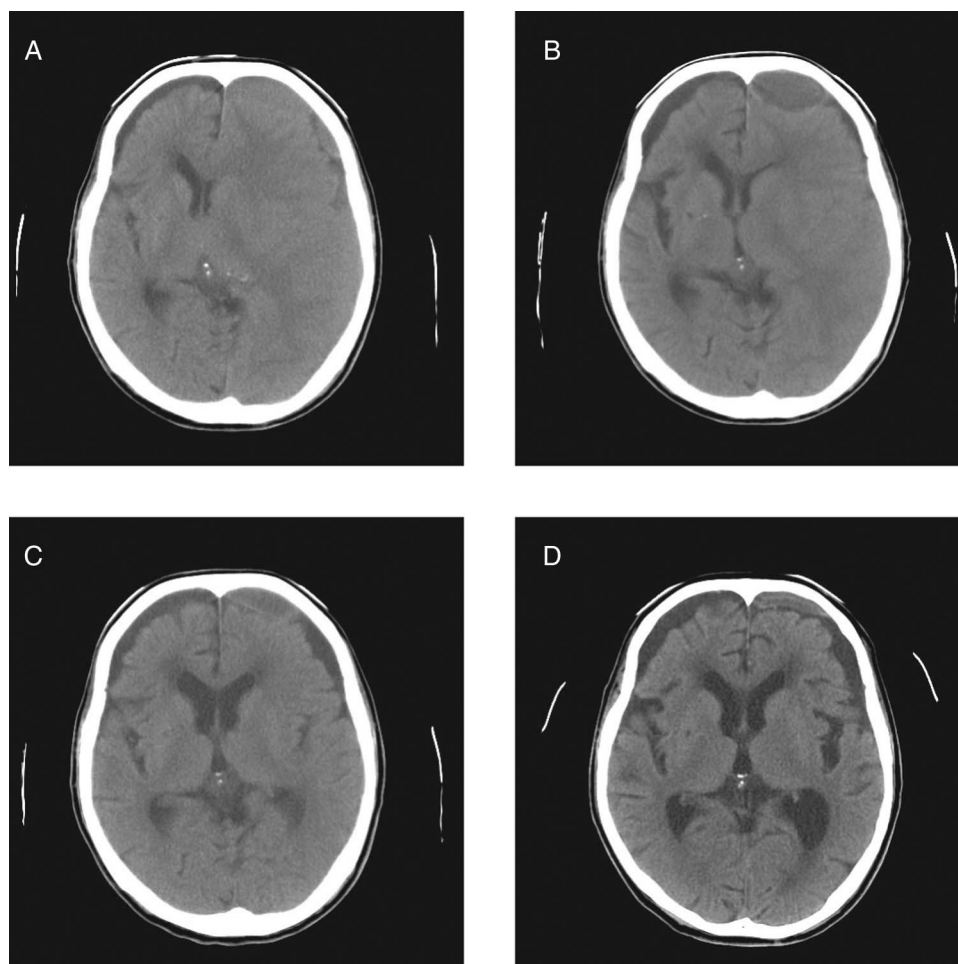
Recovery of brain damage. (A) Cerebral CT scan on admission. (B) Cerebral CT scan on day 127. (C) Cerebral CT scan on day 189. (D) Cerebral CT scan on day 520.
